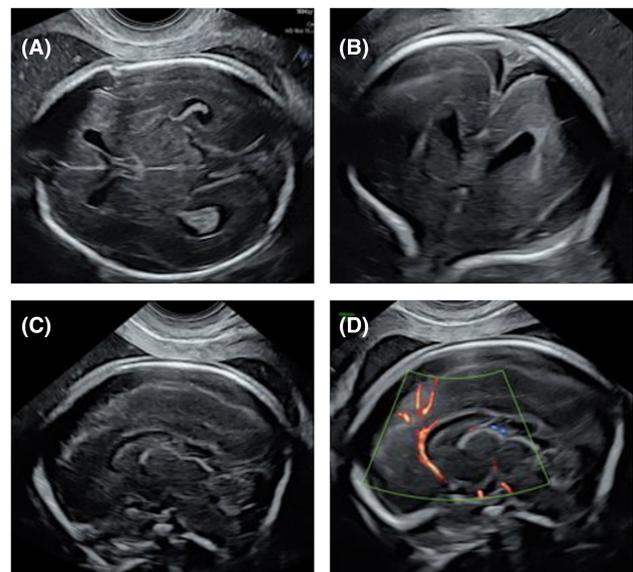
Fetal ultrasound showing an obliterated cavum septi pellucidi (oCSP) in the axial (A), coronal (B) and sagittal (C) planes, with pericallosal artery in (D).
